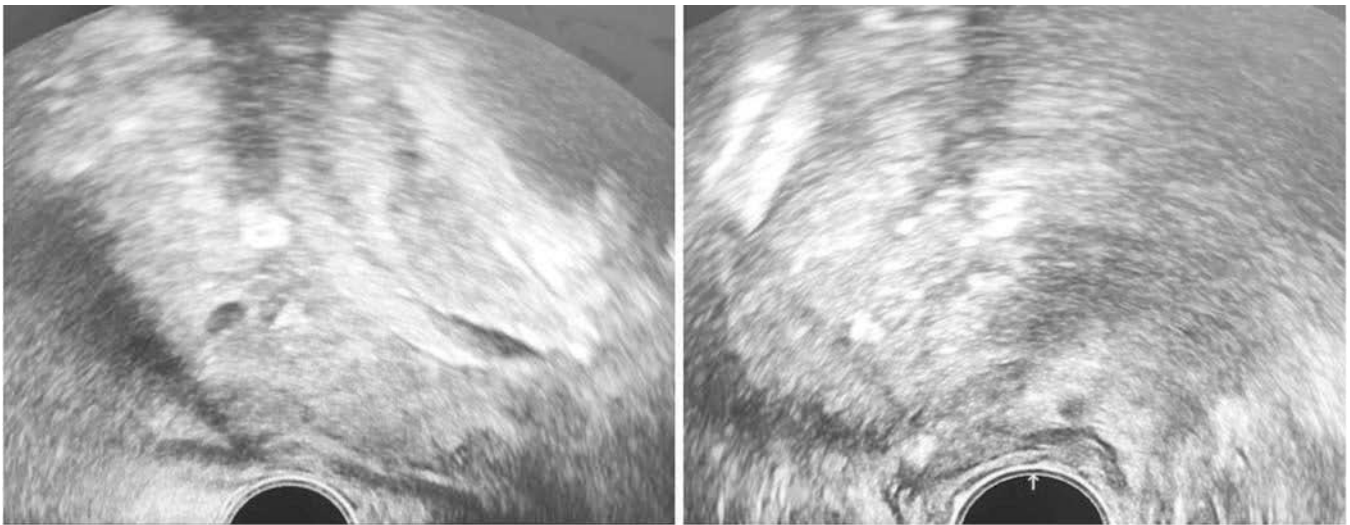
Transrectal ultrasound images of the prostate.
